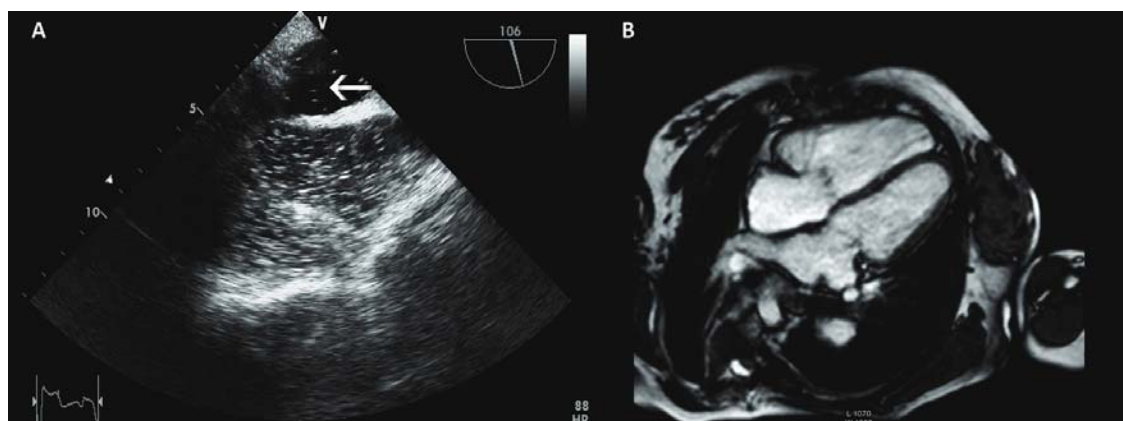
A) Transesophageal echocardiogram showing passage of the contrast from the right to the left atrium (arrow); B) Cardiac magnetic resonance imaging showing no visible communication between the two atria.
